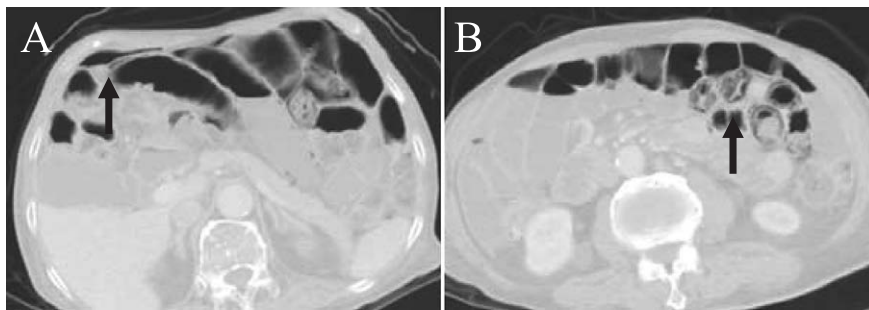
Abdominal CT performed on the day of admission
